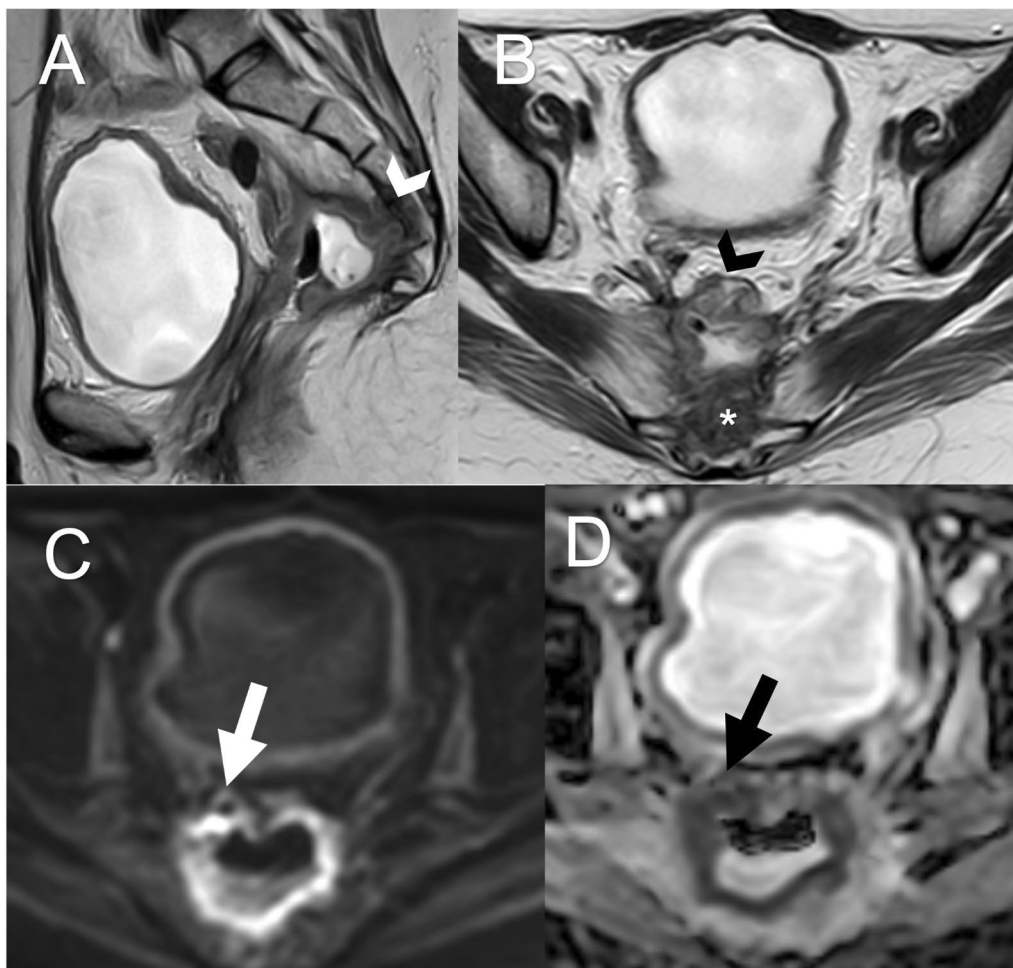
47-year-old female patient with history of rectal cancer, underwent surgical resection and ileostomy, received chemo and radiotherapy, complained of bleeding per rectum and coccydynia, and was referred for assessment by MRI with administration of rectal gel. A Sagittal T2 weighted image revealed tumoral recurrence (white arrow head) mainly along the posterior wall of the rectum infiltrating the tip of the coccyx. B Axial T2 weighted images showed the recurrent tumour (black arrow head) infiltrating the coccyx (asterisk). C and D Axial DWIs and ADC map images show the same recurrent tumour as evidenced by marked diffusion restriction (white arrow) with corresponding low ADC value (black arrow)
